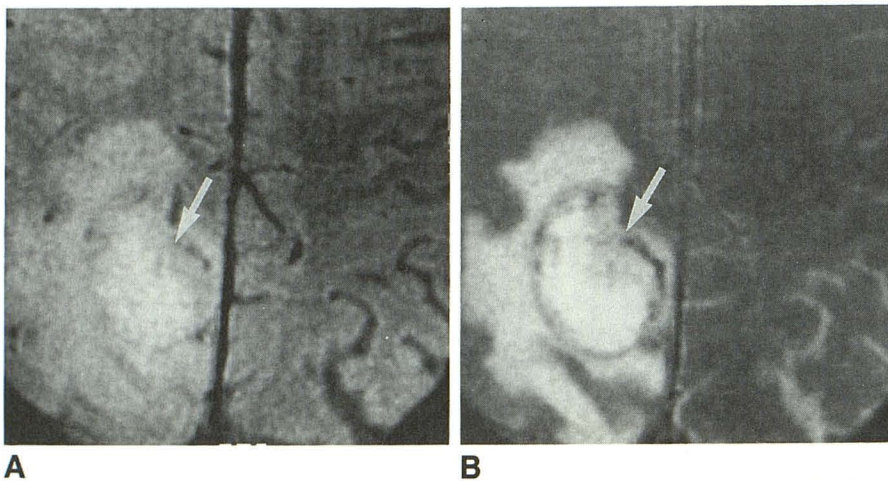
Case 46: 49-year-old man with biopsy proved toxoplasmosis. A and B, Proton-density (A) and T2-weighted (B) axial MR images (2000/80) show abscess (arrow) with marked peripheral edema surrounding it. Biopsy revealed toxoplasmosis.
